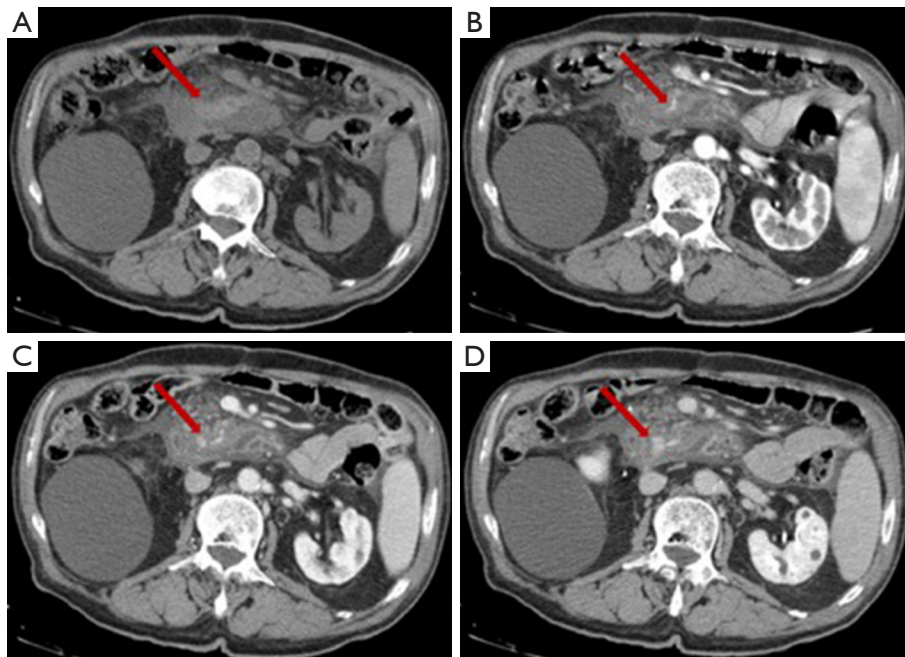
Haemorrhage on CT examination (red arrows): in unenhanced phase (A), parenchymal phase (B), portal phase (C) and in delayed phase (D).
